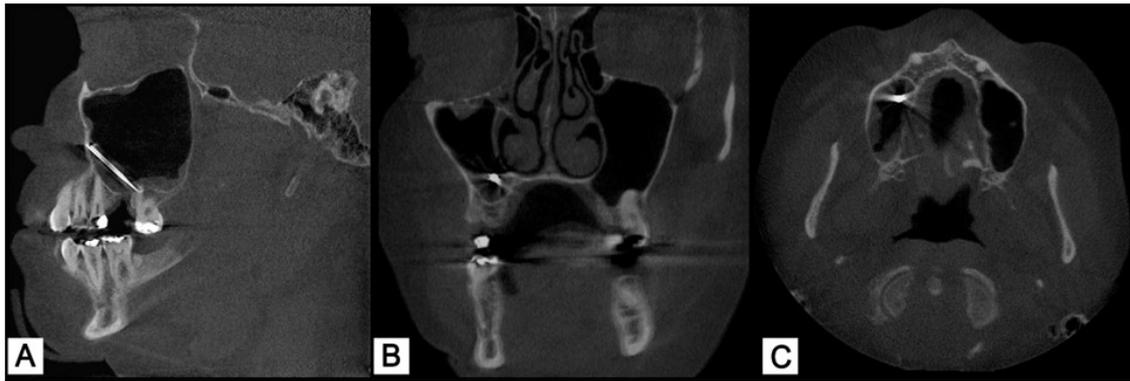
A - CBCT in sagittal section showing the correct positioning of the object in the right MS; B and C - CBCT in coronal and axial sections showing, respectively, an intensely hyperdense image surrounded by an opaque area in the right MS.
